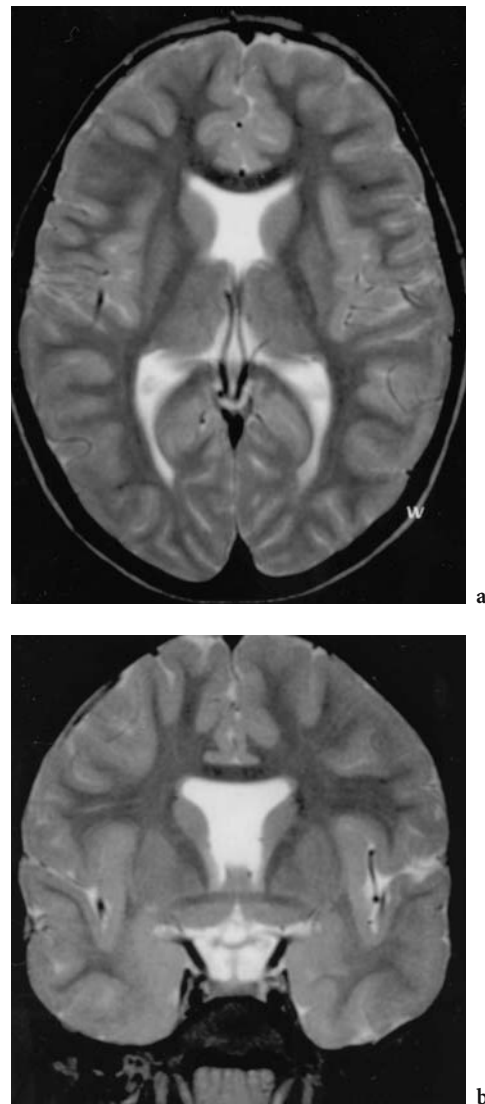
a Axial, b coronal T2-/FSE MRI of a 4-year-old boy. Clinically convergent strabismus and bilateral optic nerve hypoplasia. MRI shows absent septum pellucidum. Diagnosis: septo-optic dysplasia. Visual acuity at 6 years: R 1.0, L <0.1
